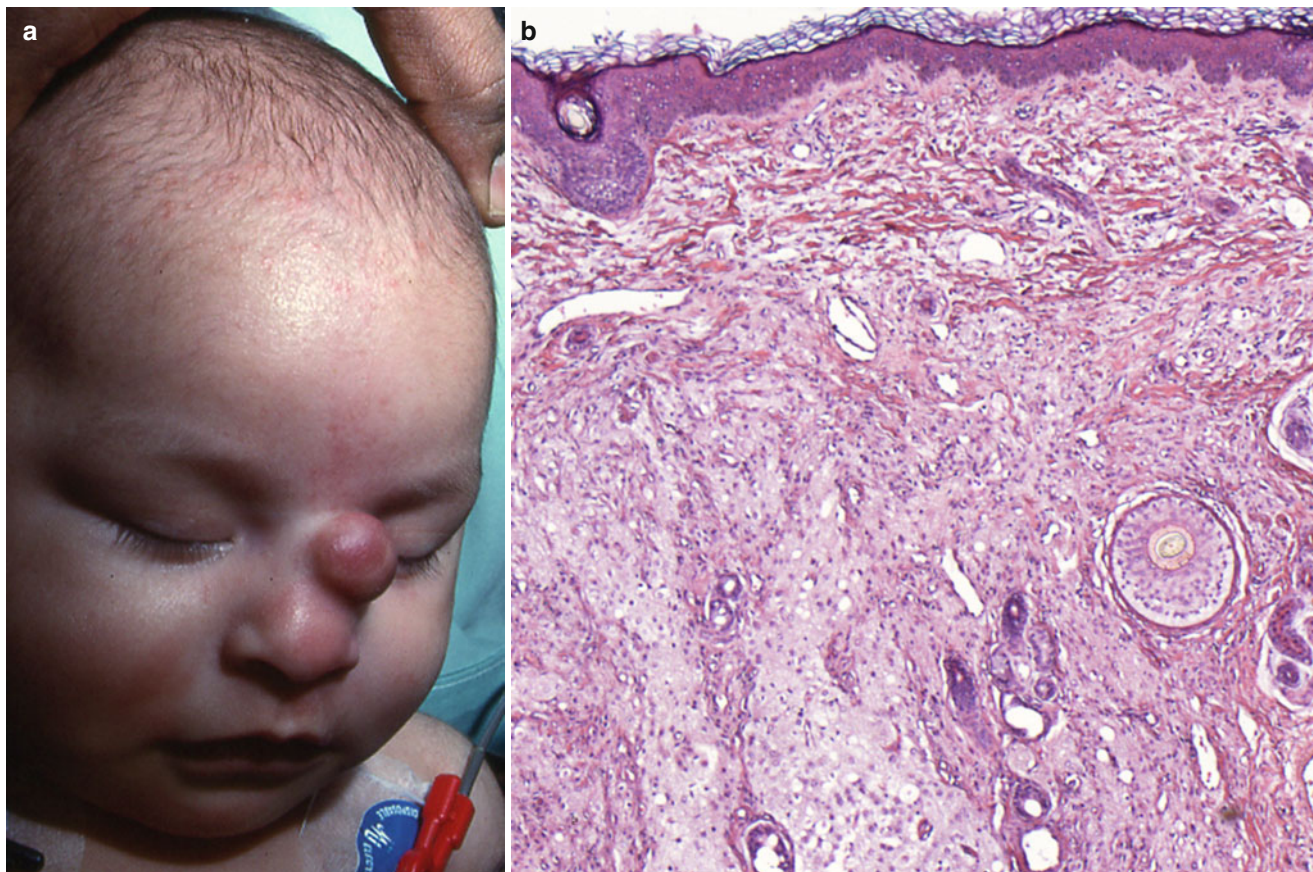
Nasal encephalocele (“nasal glioma”). (a) Newborn with a firm, round nodule situated on the bridge of the nose. Intracranial CT scan does not reveal a communication with the brain. The nasal mass
